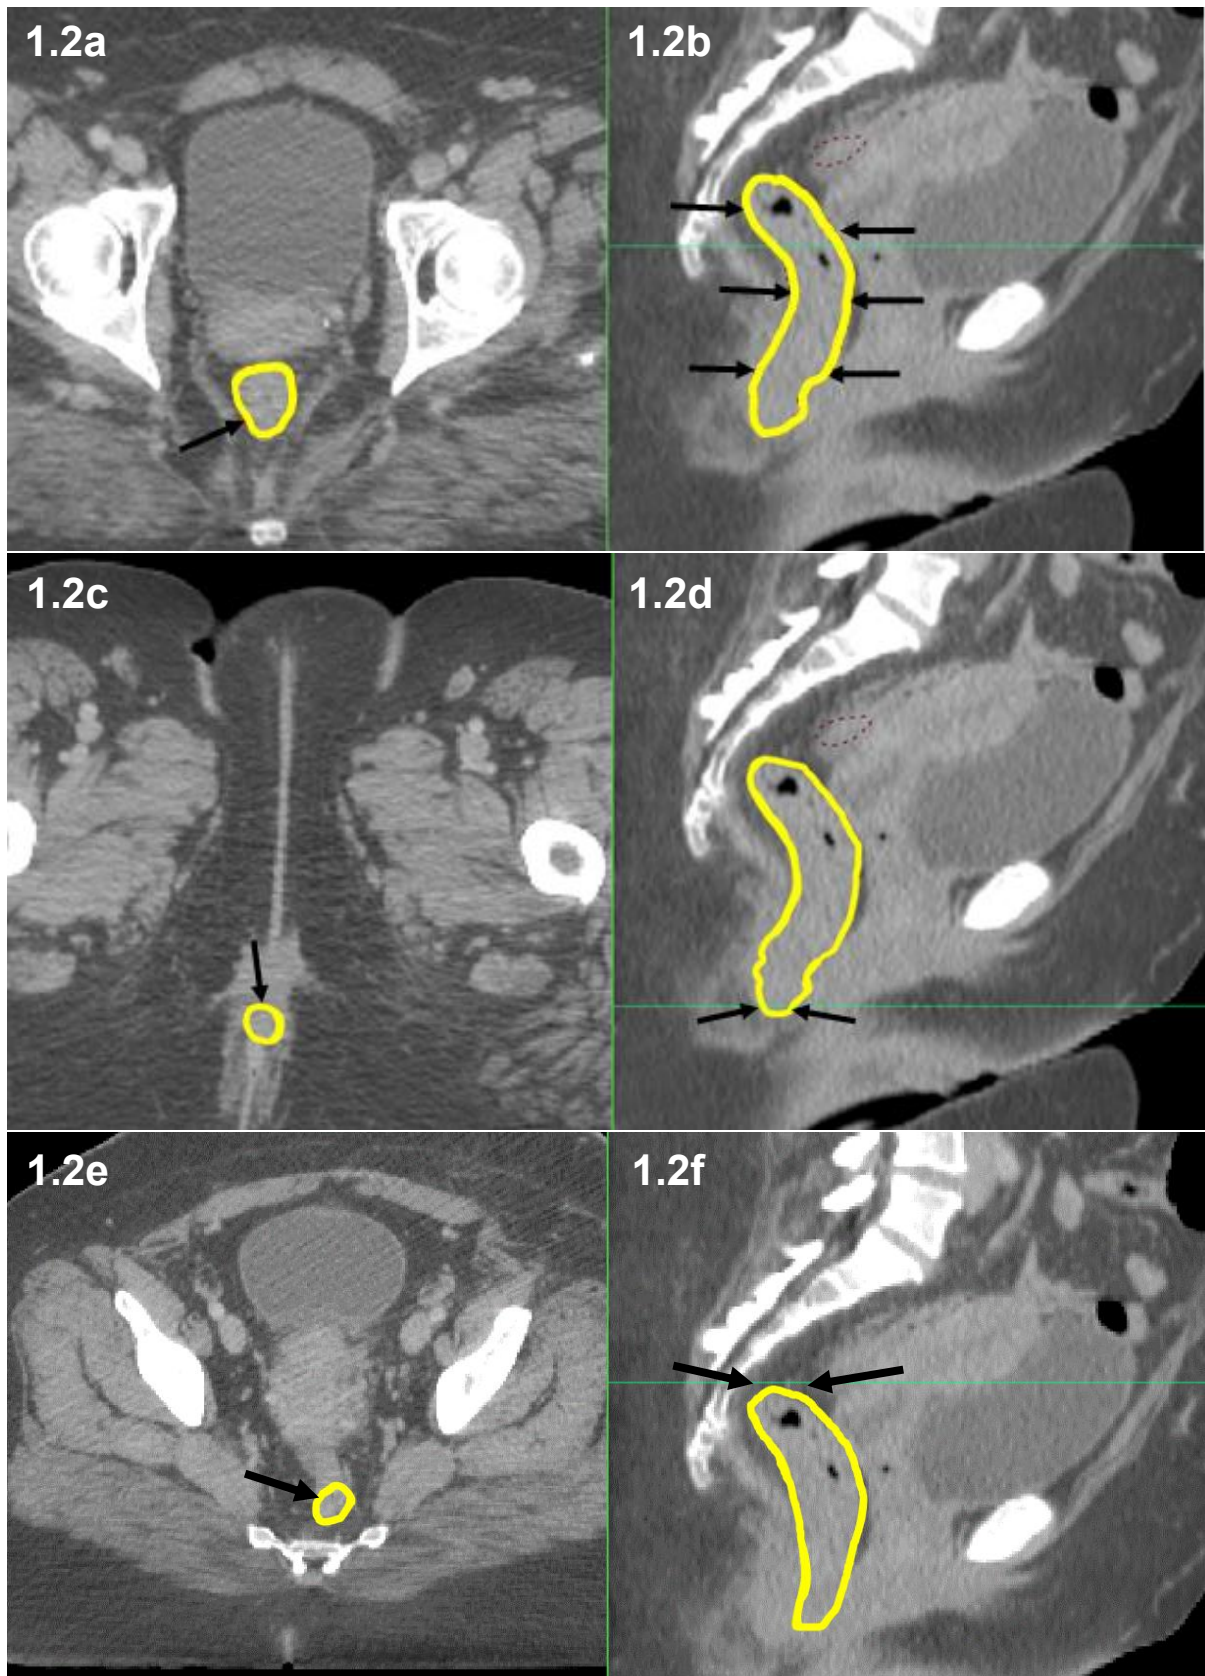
Transverse (a) and Sagittal (b) CT at level of mid-femoral heads with rectum outlined (arrowed in a and b); Transverse (c) and sagittal (d) CT at level of anus (arrowed in c and d); Transverse (e) and sagittal (f) CT at level of transition anteriorly into sigmoid colon (arrowed in e and f).
